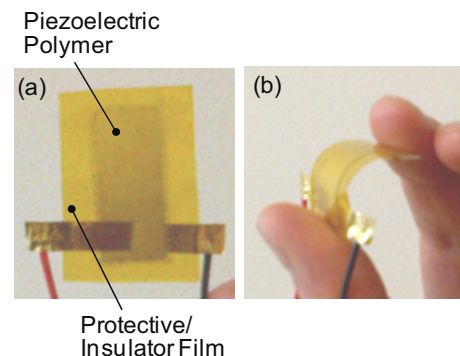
Photographs of an ultrasonic transducer developed: top view (a) and side view with bending (b).
